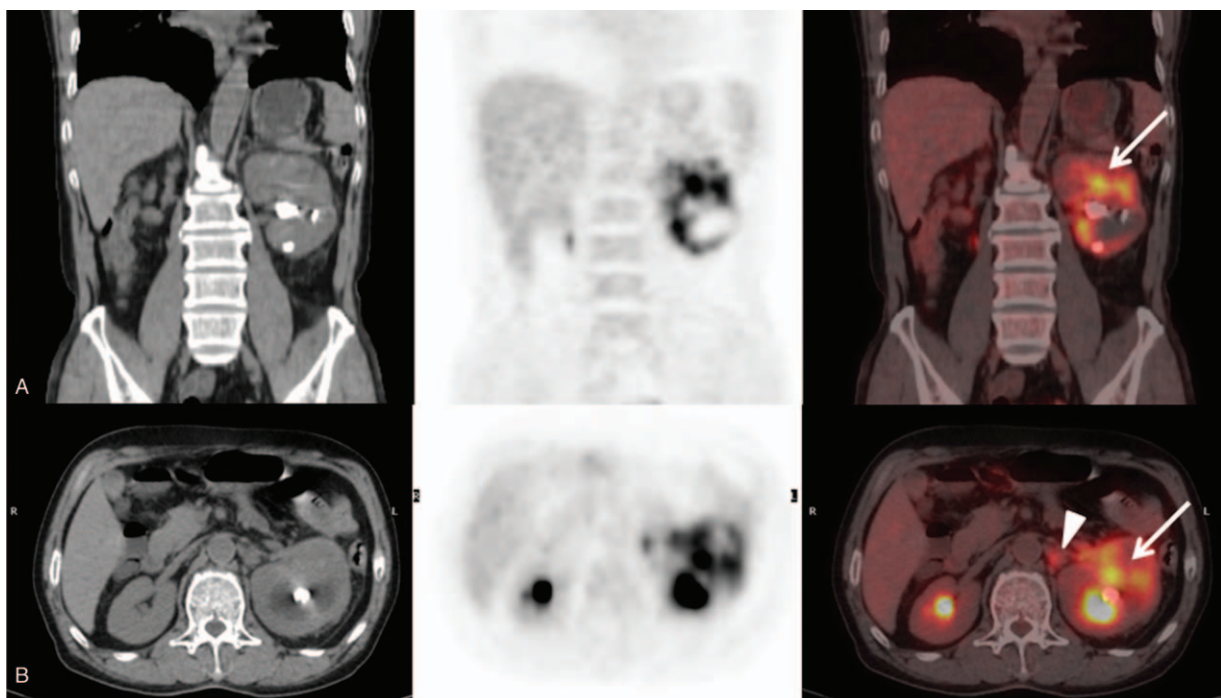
Coronal CT (A) demonstrated complex cystic lesions of the left kidney with few septae (white arrow) and calculi in the pelvis. Axial CT (B) showed no contrast excretion by partial left kidney. CT = computed tomography.
